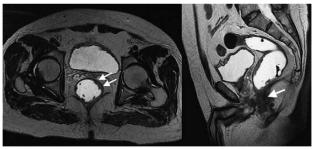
MRI axial sequence with axial T2 information. A mass is identified in the anterior wall of the rectum between 12 and 4 o'clock, 7 cm from the anal flange, approximately 40 mm long and 7 mm thick, extending to the muscle, compatible with a T2 stage cancer.
